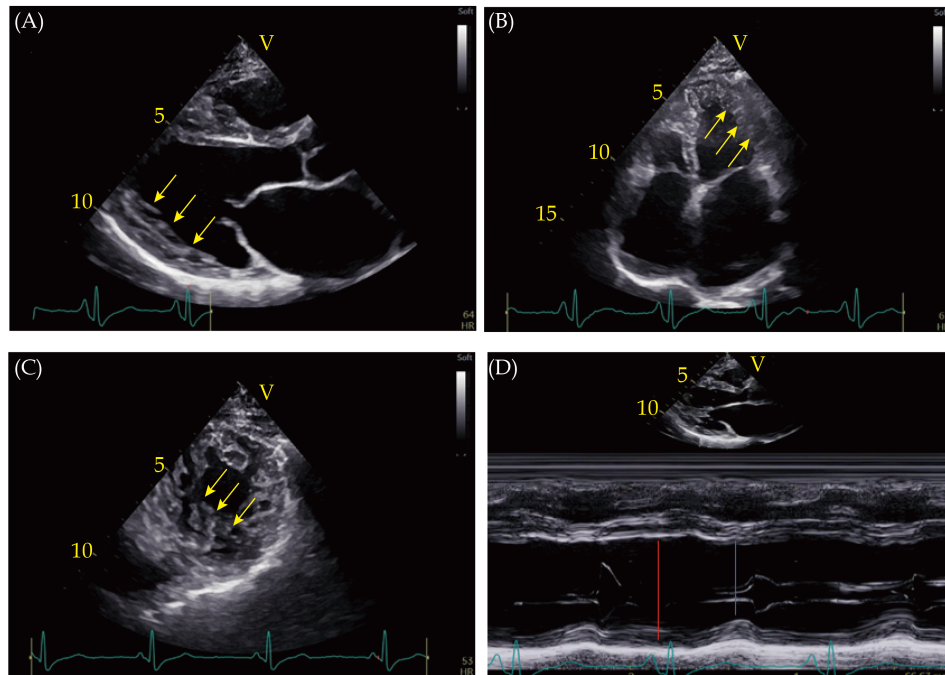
Echocardiogram images showing the characteristic spongy appearance of noncompaction (indicated by yellow arrows) and left ventricular dilation in the proband (A); long axis section of left ventricle (B); apical four chamber section (C); and short axis section of left ventricle (D) M mode. LVEDD indicated by red line, LVESD indicated by blue line. LVEDD: left ventricle end diastolic dimension; LVESD: left ventricular end-systolic diameters.
